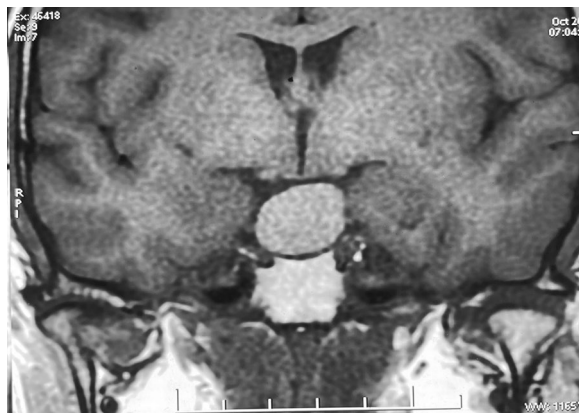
MRI brain T1 coronal image showing the entirely suprasellar location of the cystic lesion
